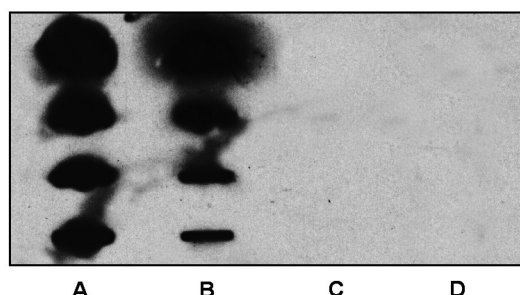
Immunological detection and relative quantification of PNAG extracted from the biofilm matrix: M187 CT (A), M187 DCX (B), M176 DCX (C); M176 CT (D). Rows 1-4 represents serial 4-fold dilutions of cell-surface extract.
